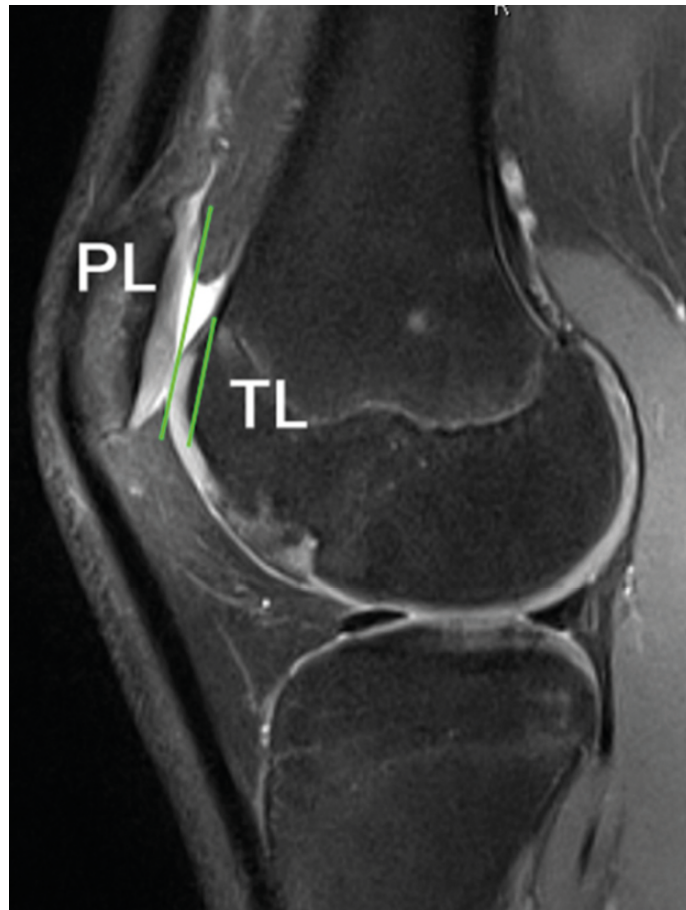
Measuring the sagittal engagement index as per Dejour et al. using sagittal MRI images.
